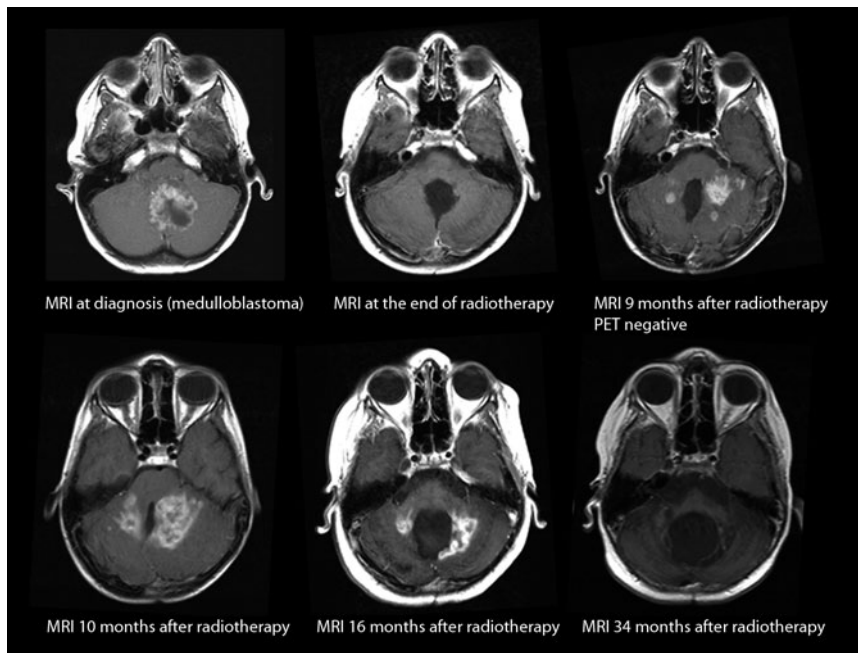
▲ Magnetic resonance imaging (MRI) of patient 3 at diagnosis, after radiotherapy and during follow-up. *PET* positron-emission tomography
